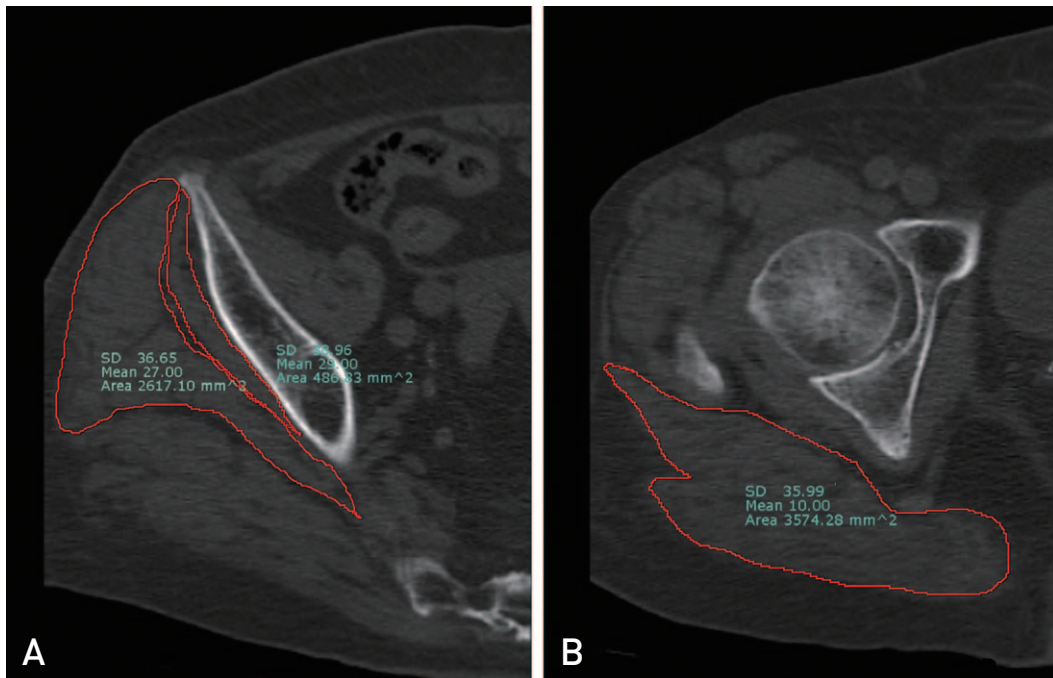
Cross sectional area measurement on axial computed tomography cut. (A) Gluteus minimus and medius area measurement on S3 level. (B) Gluteus maximus area measurement on greater trochanter tip level.
